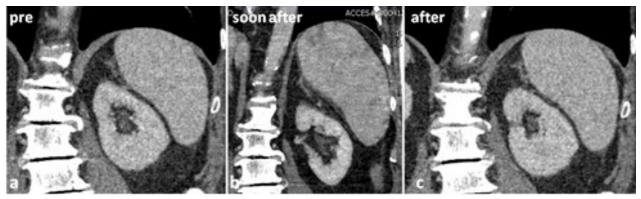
Coronal CT images compared splenic parenchyma before (a), soon after (b) and 1 month after (c) the procedure.
